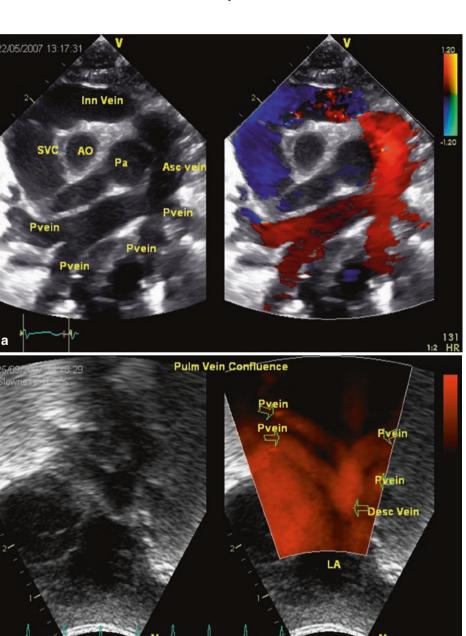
(a, b) Echocardiographic image: supracardiac total anomalous
